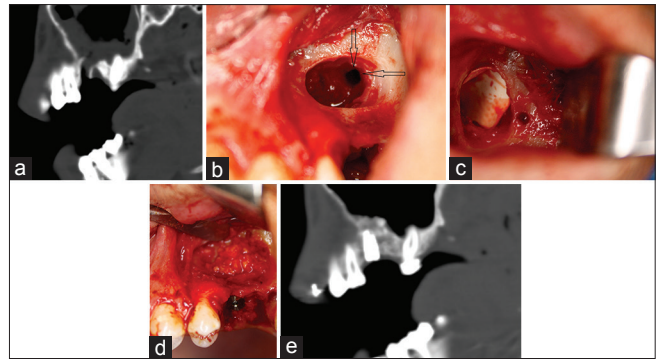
(a) Radiographic appearance of extraction tooth socket of Case 2, (b) Sinus membrane was elevated carefully around the perforation area, (c) A barrier membrane was used to close the perforation, (d) The particulate graft and a dental implant was performed simultaneously, (e) Postoperative computed tomographic appearance, 40 months after surgery
